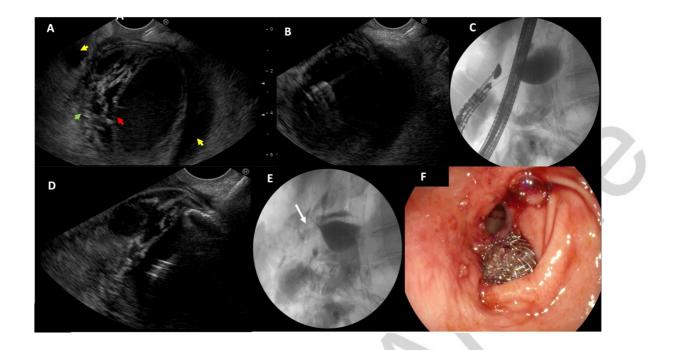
EUS-guided gallbladder drainage of perforated cholecystitis.* A. Endosonographic vision of acute perforated cholecystitis type II according to the Niemier classification. Note the distended gallbladder, with the double wall sign and the "hole sign" (red arrow), with trabeculations of the adjacent fat (green arrow) and perivesicular fluid collections (yellow arrows). B and C. Endosonographic and fluoroscopic image of the gallbladder puncture with a 19-gauge needle during contrast injection. D. Endosonographic vision of deployment of the internal flange of the LAMS into the gallbladder. E and F. Fluoroscopic and endoscopic image of the cholecystogastrostomy after the release of the LAMS (white arrow). LAMS: lumen-apposing metal stent.
